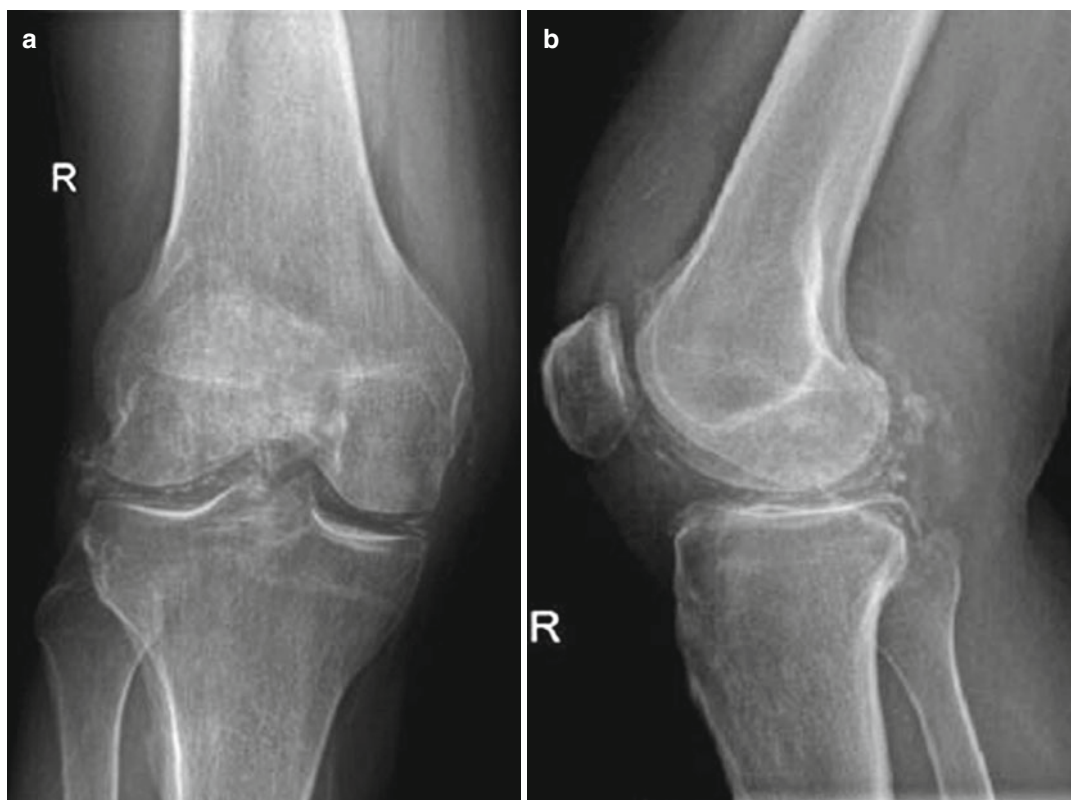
(a, b) Right knee radiography shows the presence of meniscus and ligament calcifications in chondrocalcinosis
